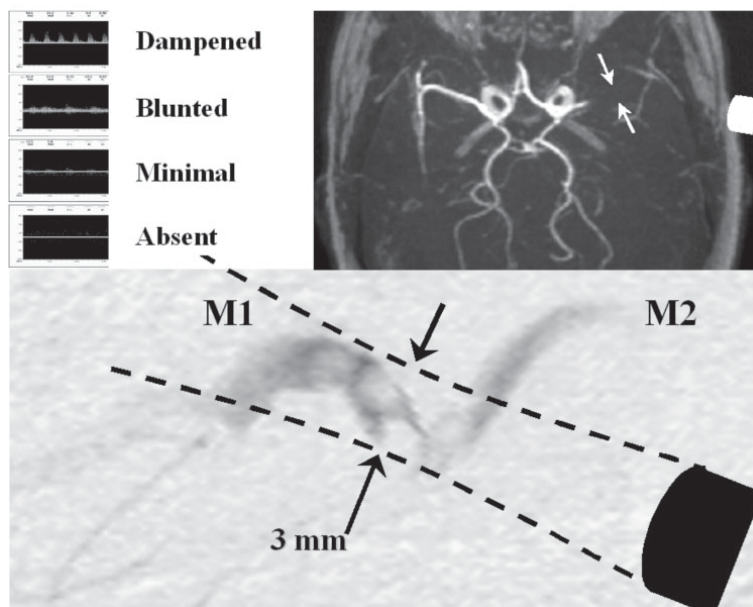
Abnormal arterial residual flow signals sampled from thrombus-residual flow interface (arrows) at the site of an acute thromboembolic MCA occlusion (reprinted with permission from Alexandrov AV. *Ultrasound identification and lysis of clots. Stroke* 2004;35(Suppl 1):2722-5).
